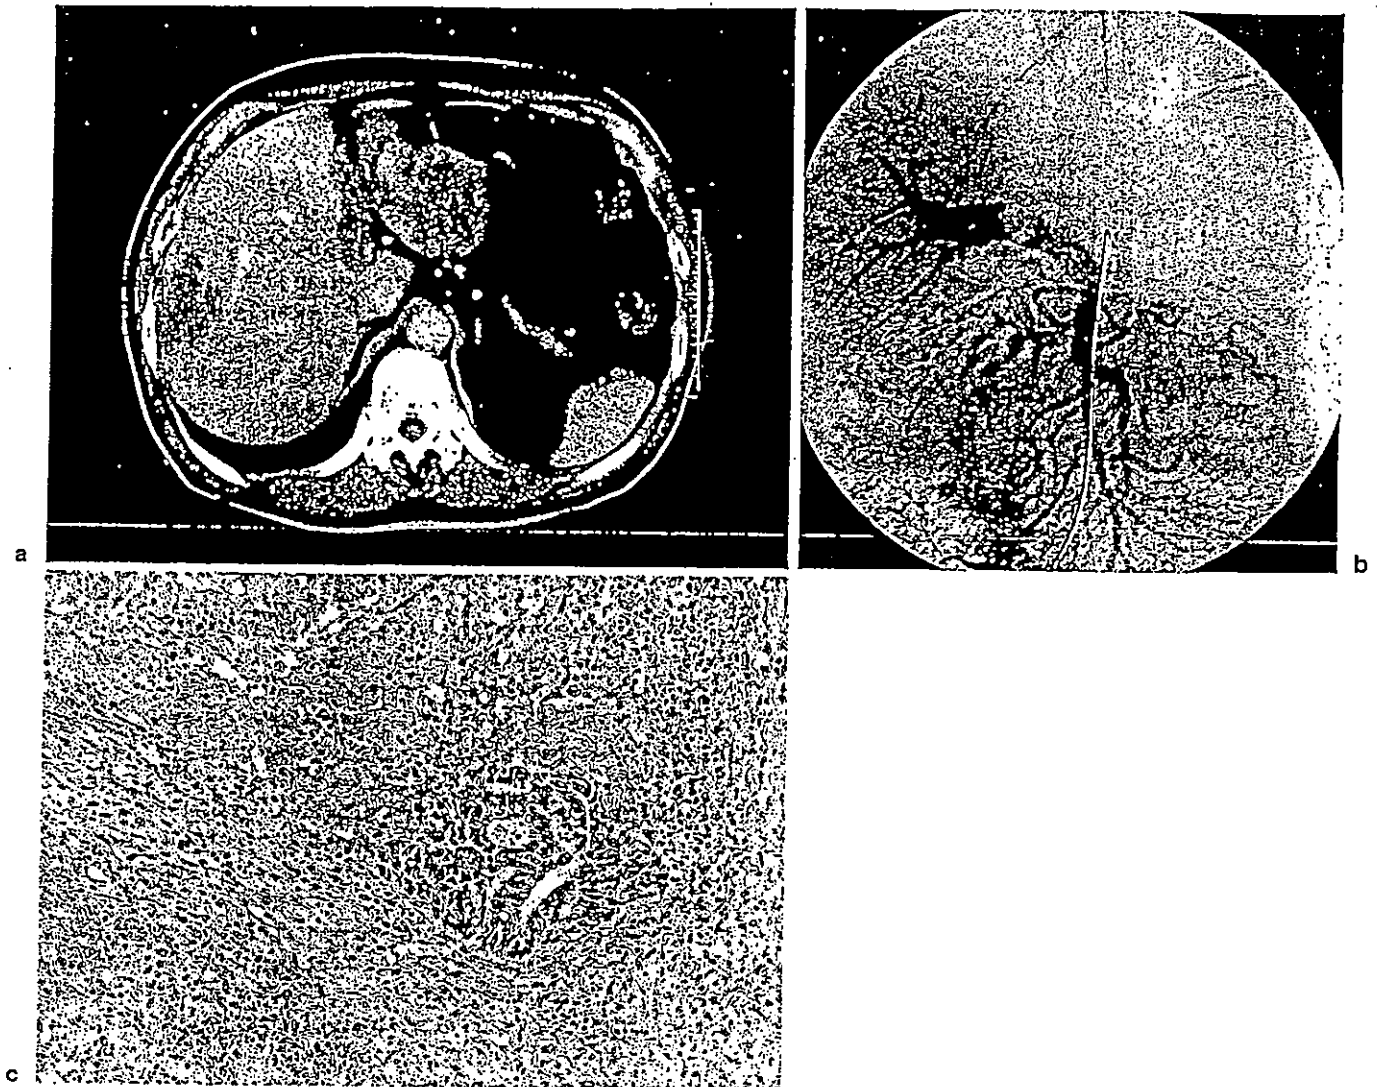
Case 4. a CT scan. Two metastatic liver tumors were located in subsegment 8 and in the left lobe. The tumor in the left lobe was associated with left portal vein tumor thrombi. The left lobe was atrophic because of left portal vein obstruction. *Arrow* indicates that the tip of the tumor thrombus reached the portal vein trunk. b Abdominal angiography. Late phase of superior mesenteric angiography indicates that the tip of the left portal vein tumor thrombus reached the bifurcation. c Pathological findings of the extirpated portal vein tumor thrombi. Adenocarcinoma proliferated in the fibrous tissue
